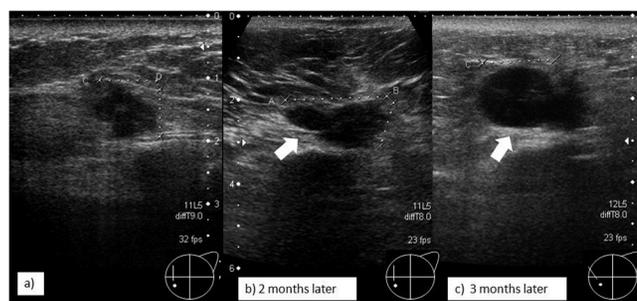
Ultrasound findings in the third lesion (mass in the left anterior chest wall).
